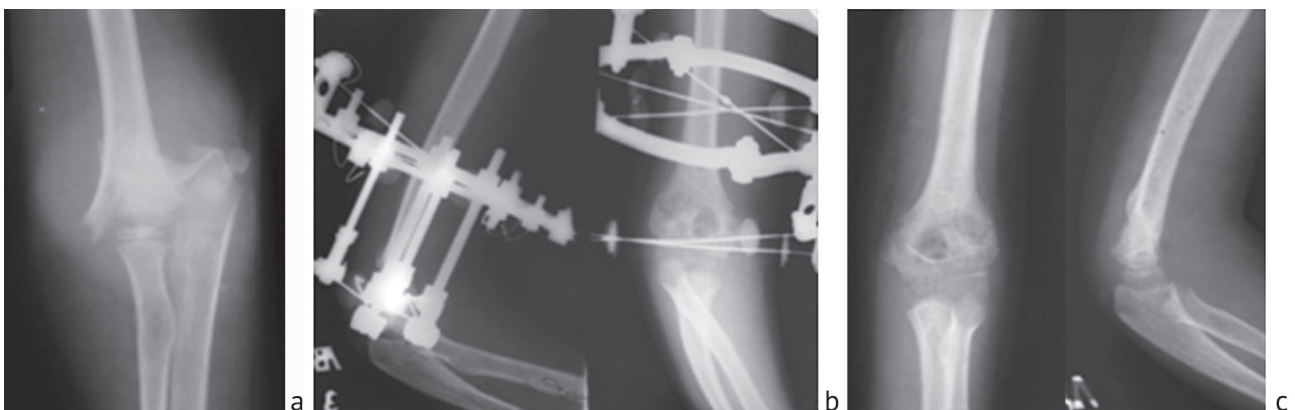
Closed supracondylar fracture of the humerus (Garland III): a X-ray of the fracture zone before surgery; b radiographs in two projections after Ilizarov osteosynthesis; c X-rays taken in two projections after dismantling the Ilizarov apparatus
